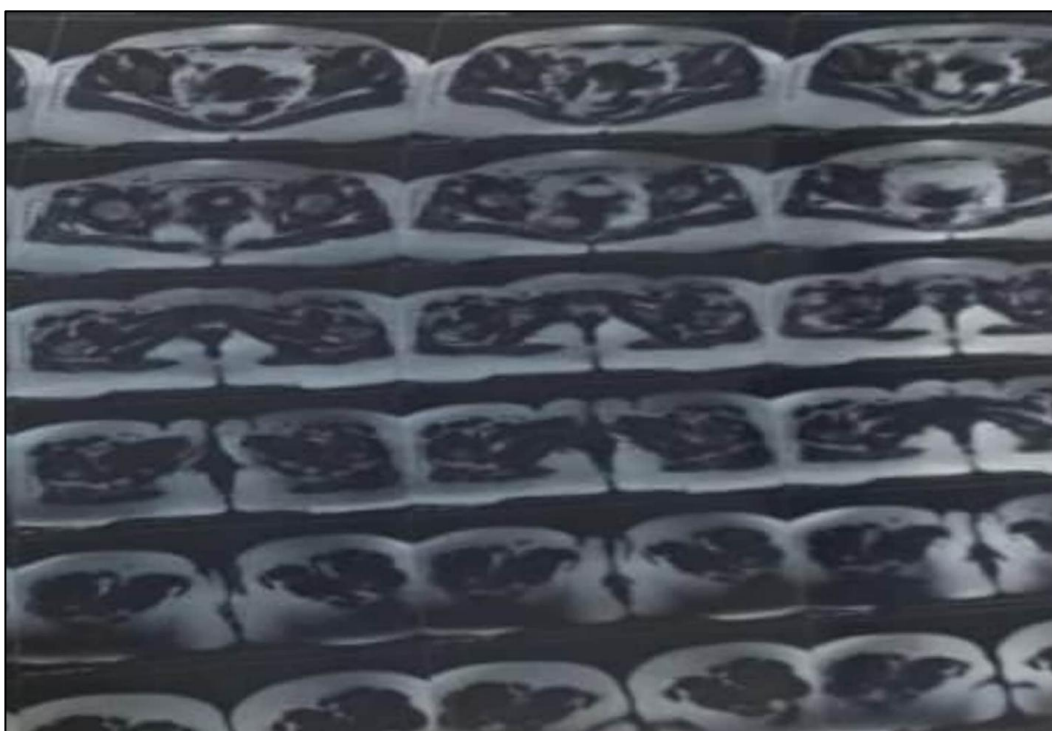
Investigation (MRI Scan)
